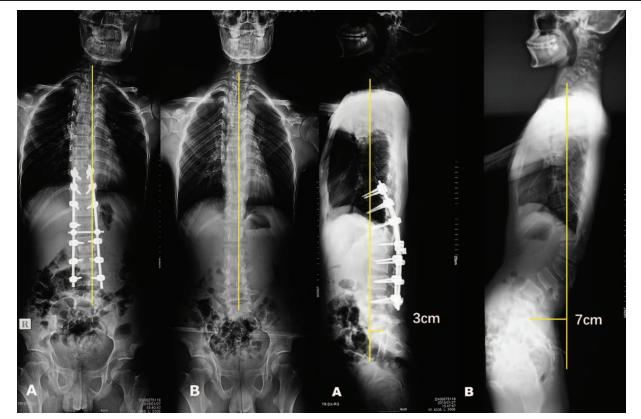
Preoperative and postoperative lateral radiographs of the proband were compared. (A) Postoperative anteroposterior and lateral radiographs; (B) preoperative anteroposterior and lateral radiographs.
